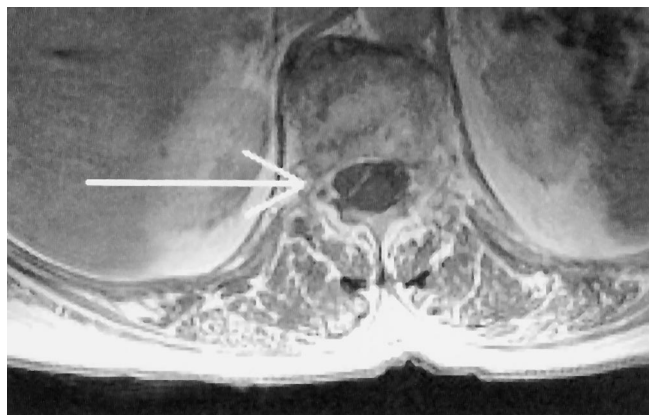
Axial magnetic resonance image showing the hematoma.
